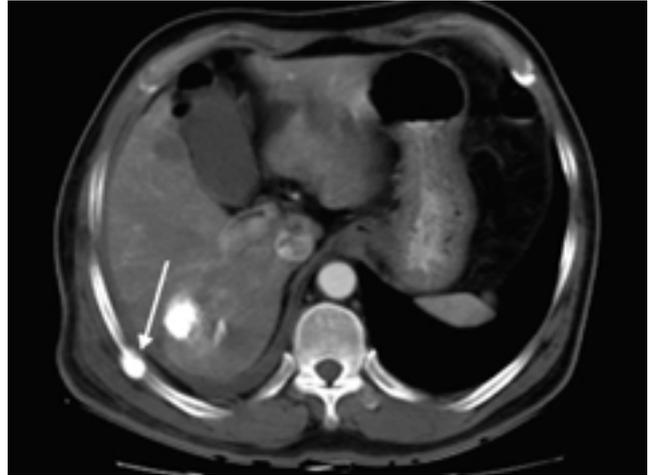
Follow-up enhanced CT scan shows that the lipiodol compactly accumulates in the metastatic tumor in the right ninth intercostal space.
